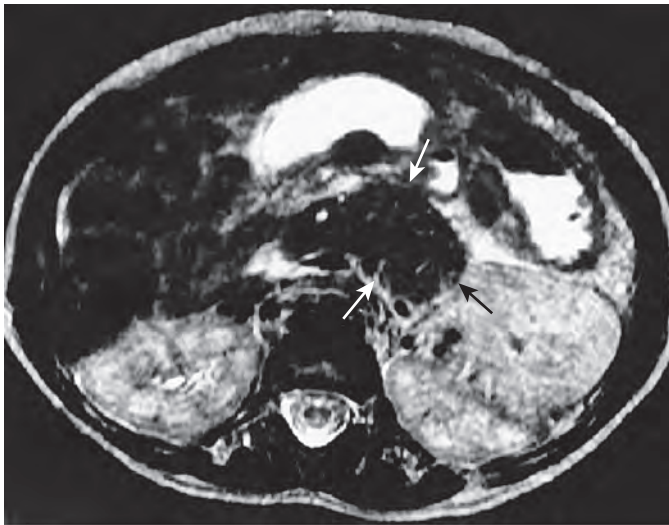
Pancreatic enlargement in Beckwith-Wiedemann syndrome. Axial-view, turbo T2-weighted MRI shows diffuse enlargement of the pancreas (arrows), which has normal signal intensity, in a 19-month-old girl with Beckwith-Wiedemann syndrome being observed for hepatoblastoma.
